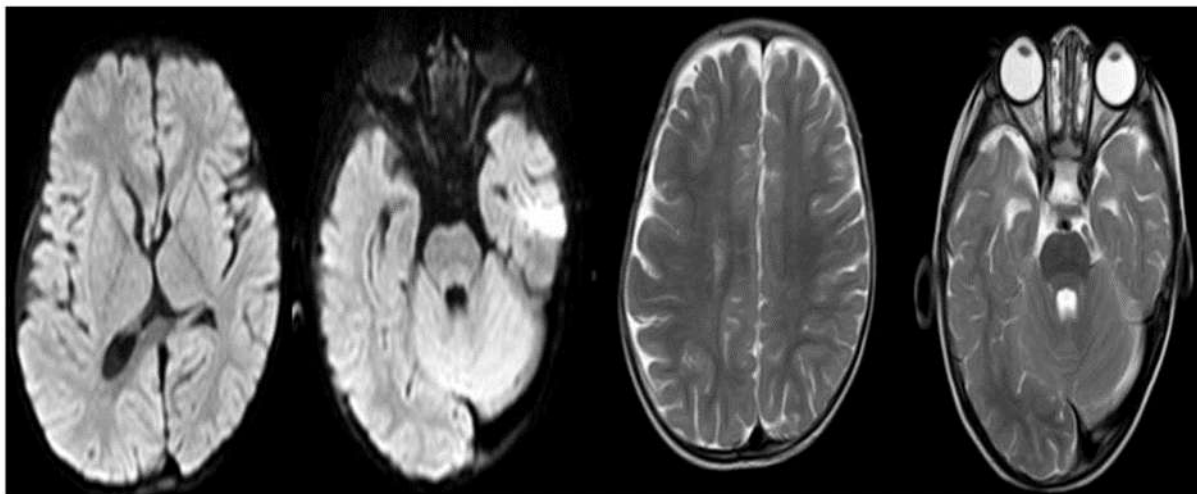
Axial FLAIR and T2W
